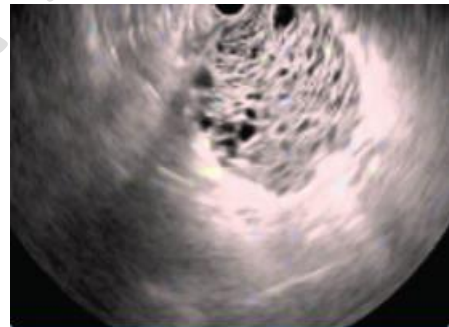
Endoscopic ultrasound image of a serous cystadenoma
